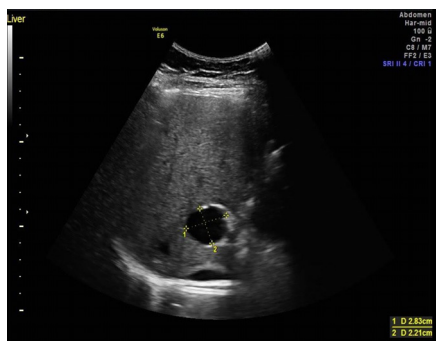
Abdominal Ultrasound. Ultrasound of the abdomen showing a solitary hepatic well-defined anechoic thick-walled cystic lesion in the right lobe of the liver and measuring 2.8 × 2.2 cm in size.
